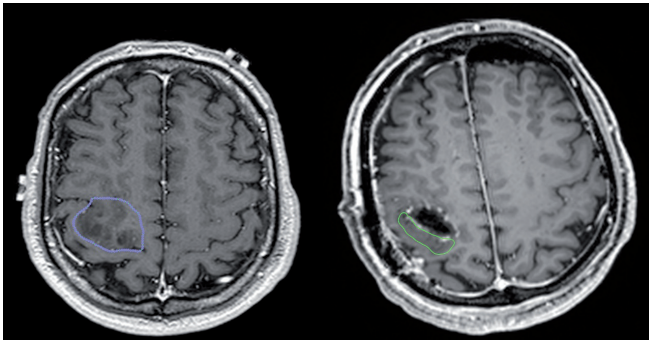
Postoperative contrast-enhanced T1 MR image (on the right side) shows the tumor residual outline, compared with pre-op lesion outline (on the left). In this patient (#2) the dramatic spatial correspondence of the tumor mass with the eloquent motor cortex, positively responsive to ECS, led to the decision to exclude the outlined portion from resection. EOR was hence subtotal (76.8%).
